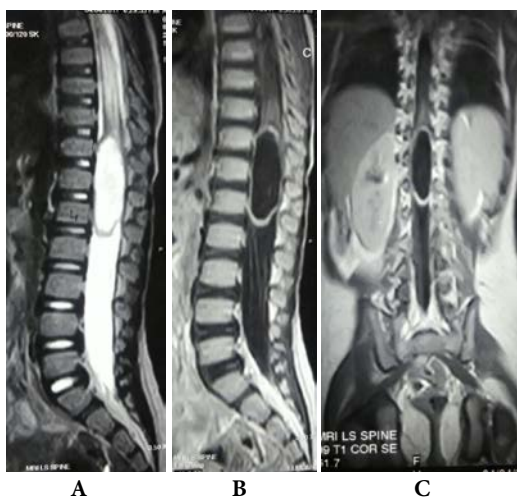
MRI T2WI of dorsolumbosacral spine, sagittal section showing wellcircumscribed, hyperintense lesion at D11-L1
